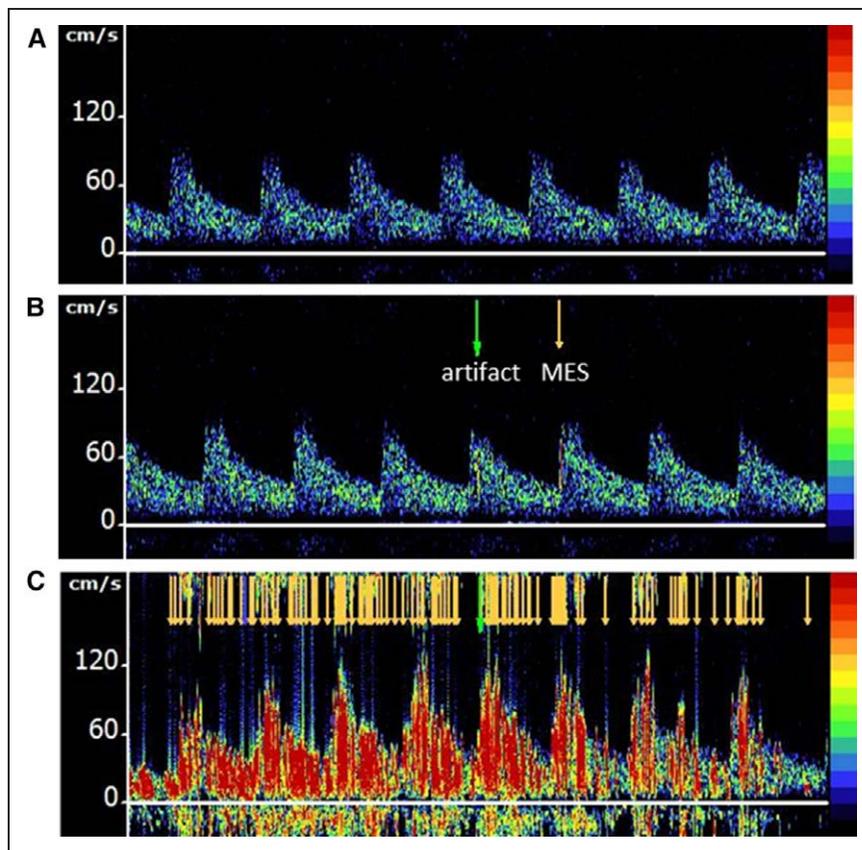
Representative pictures of transcranial Doppler microembolic signal (MES) images showing a baseline curve (A), solitary MES (B), and a burst of MESs (C). The yellow arrows indicate MESs and green arrows artifact.
